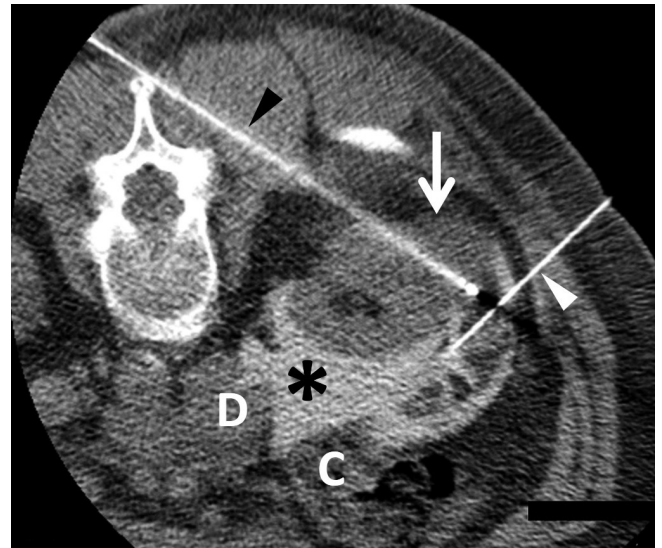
Percutaneous RFA in a 70-year-old female. Non-contrast axial CT image showing hyperattenuating iodine-containing fluid (asterisk) instilled for hydrodissection through a 22-gauge needle (white arrowhead), leading to the displacement of the colon (C) and duodenum (D) neighboring the renal cell carcinoma. One (black arrowhead) of the three RF electrodes is placed within the tumor (arrow), and RFA is performed using a switching controller. RFA = radiofrequency ablation
